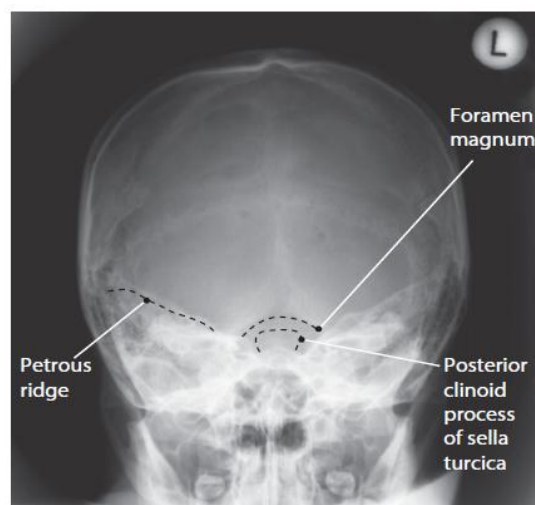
FO 30° radiograph showing anatomical features.
